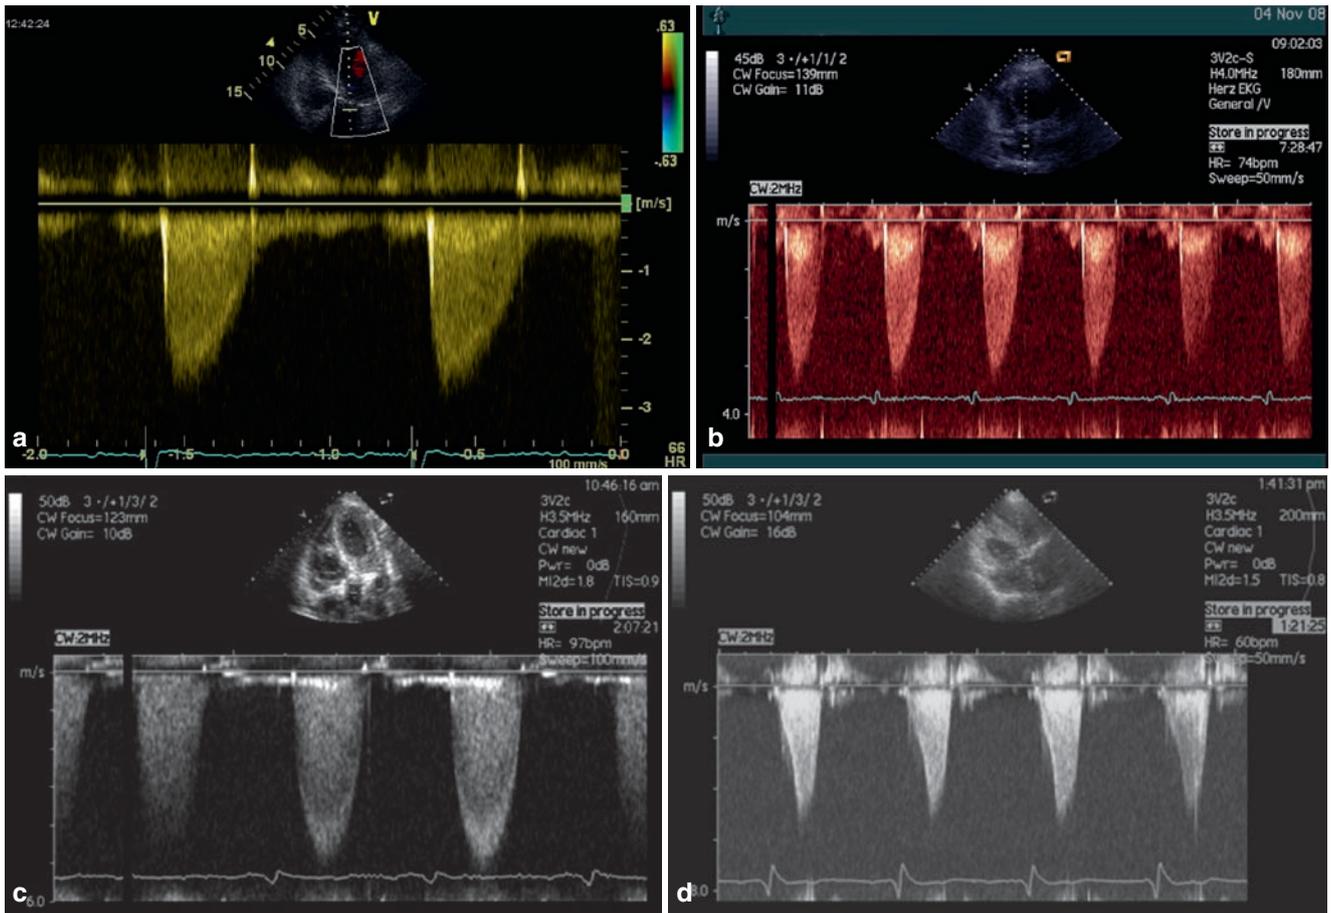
CW Doppler velocity spectrum. (a) Mild AS with immediate peak. (b) Moderate AS with early peak. (c) Severe AS with midsystolic peak. (d) Dynamic obstruction in the setting of a hypertrophic obstructive cardiomyopathy with late peak
